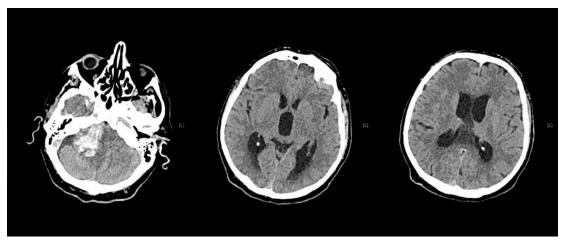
CT scan performed at the county hospital due to the sudden patient's neurological decompensation reveals bleeding in the right cerebellopontine angle (CPA) with enlargement of the lateral ventricles, suggestive of obstructive hydrocephalus.
